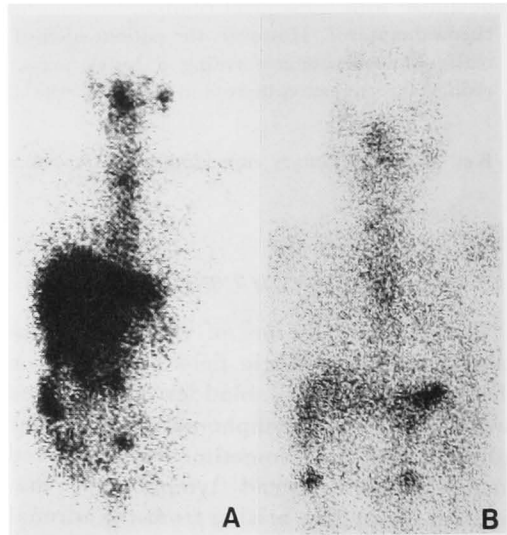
$^{67}\text{Ga}$  scintigram also shows complete disappearance of the right adrenal tumor. (A: Before B: After the chemotherapy)
